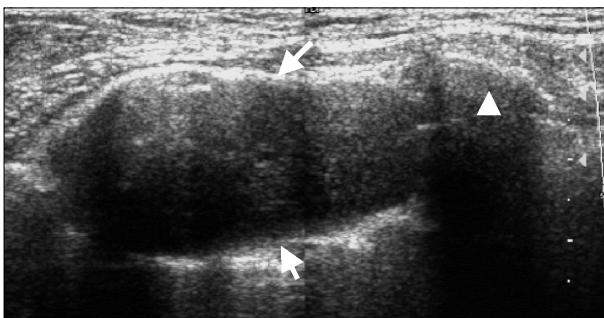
Sonography showed a well defined, oval shaped, hypoechoic mass (arrows) involving a rib (arrowhead).
